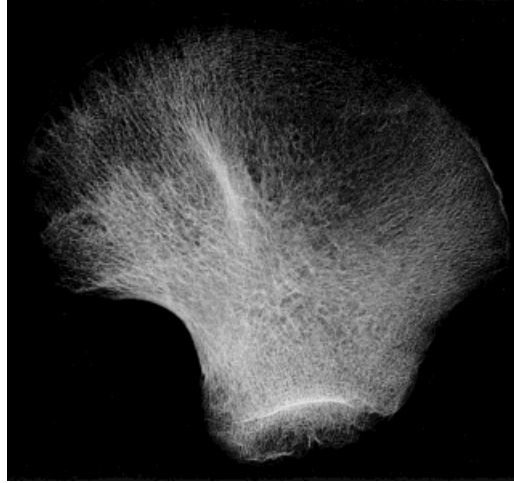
Anterior-posterior x-ray view of iliac crest (HTH 1115). Focal lytic areas at epiphyseal margin of iliac crest.
